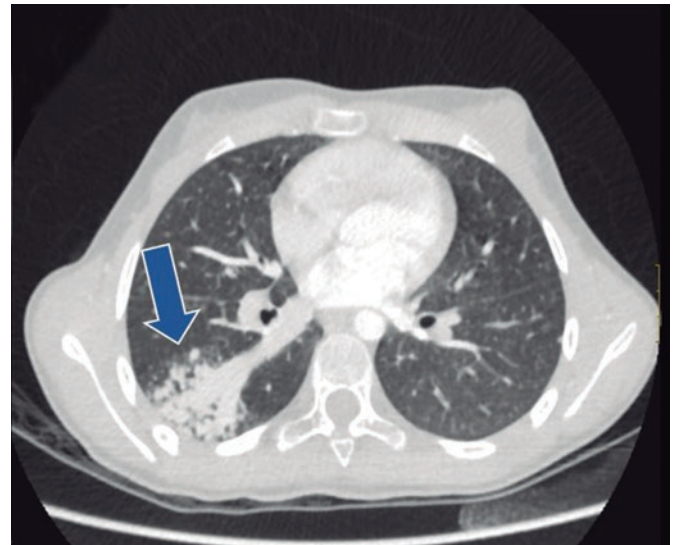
Pulmonary arteriovenous malformation seen on the thoracic computed tomography scan (arrow).
